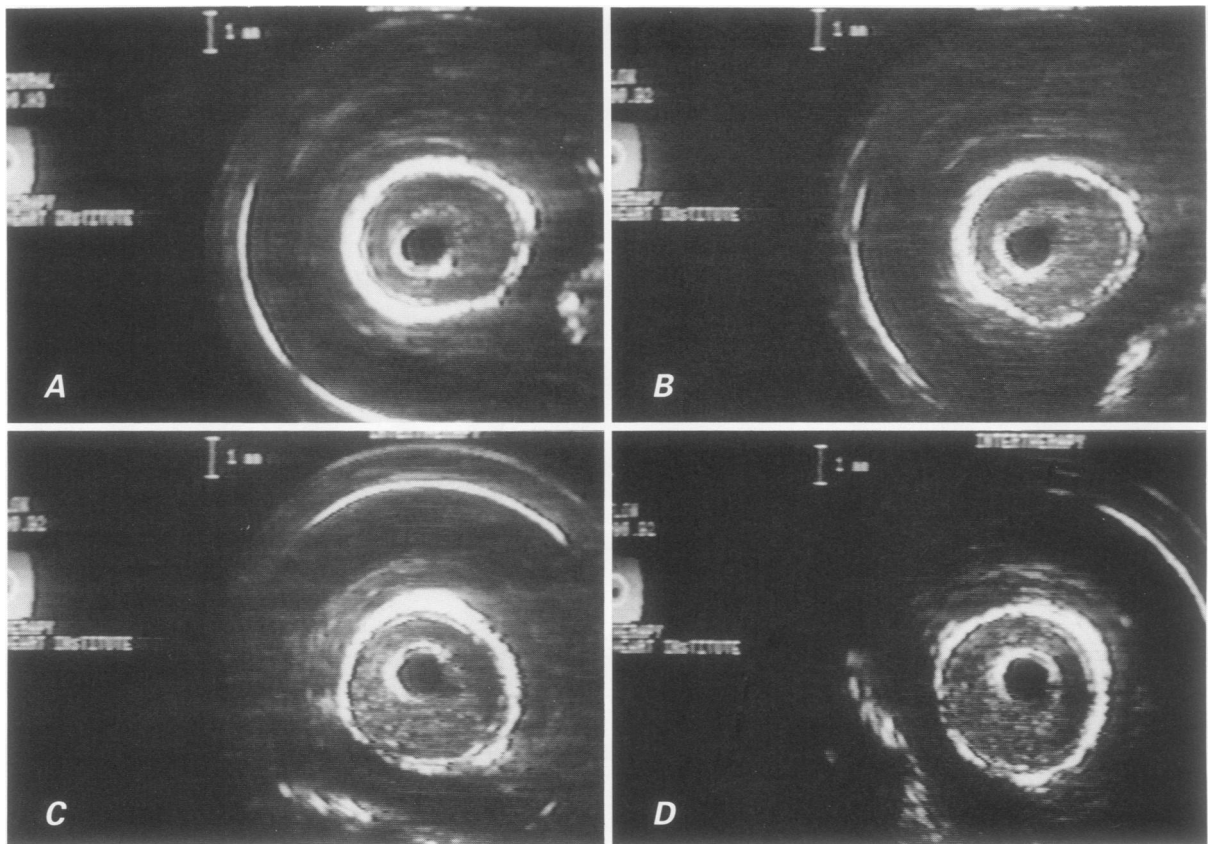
Sequential intravascular ultrasound images during a prolonged (1 hour) period of zero flow. Images are shown: A) at near zero flow; B) after 10 minutes; C) after 30 minutes; and D) after 1 hour. The "speckled" appearance of the thrombus changes over time.
